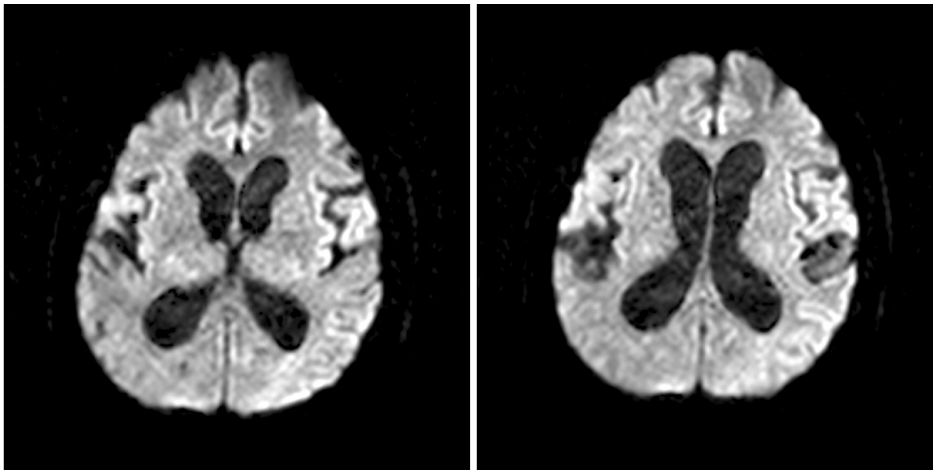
There were no abnormal findings such as acute infarction or cortical atrophy, but communicating hydrocephalus was suspected in diffusion weighted brain MRI.
